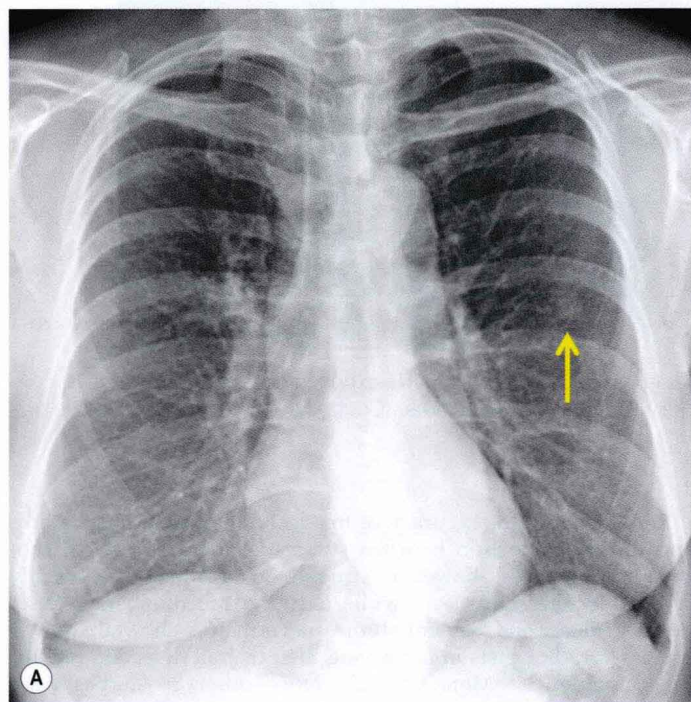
Dual-energy subtraction. A, Frontal chest radiograph shows possible left lung nodule (arrow). B, Bone subtracted image shows no evidence of nodule. C, Soft tissue subtracted image shows nodular opacity consistent with callus from healing rib fracture (yellow arrow). Note motion-induced artifact along the left heart border (red arrow). (Courtesy of H Page McAdams, Durham, NC, USA.)
